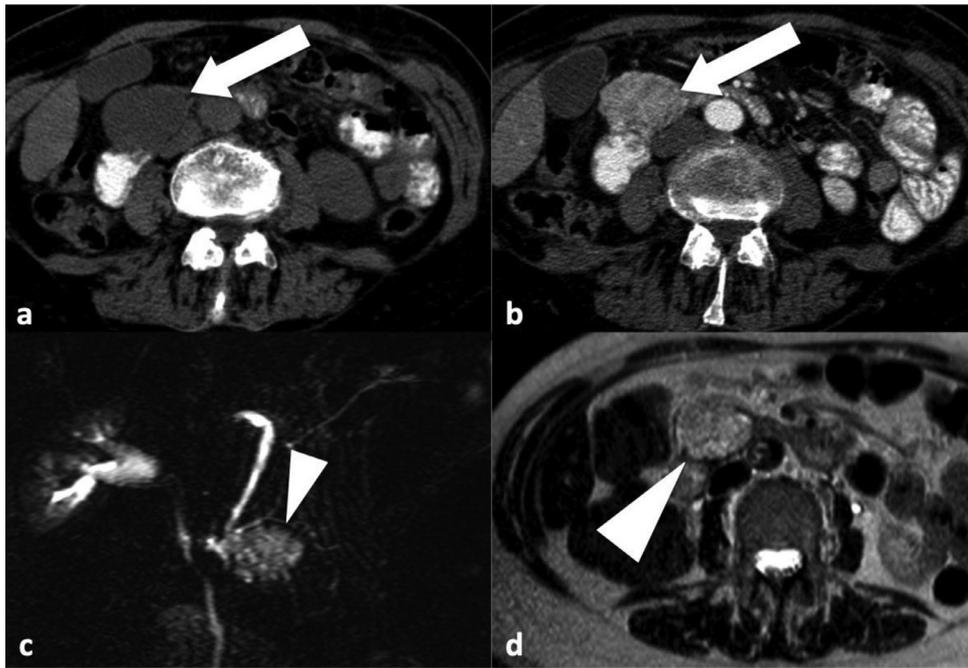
“Solid” variant of serous cystadenoma in a 62 year-old female. Precontrast (a) CT image shows a pancreatic lesion (arrow) with cystic attenuation. Enhanced (b) CT image obtained during the arterial phase shows marked and slightly heterogeneous enhancement of the lesion (b—arrow). MR cholangiopancreatography image (c) and T2-weighted MR image (d) confirmed the microcystic nature (arrowheads) of the tumor.
